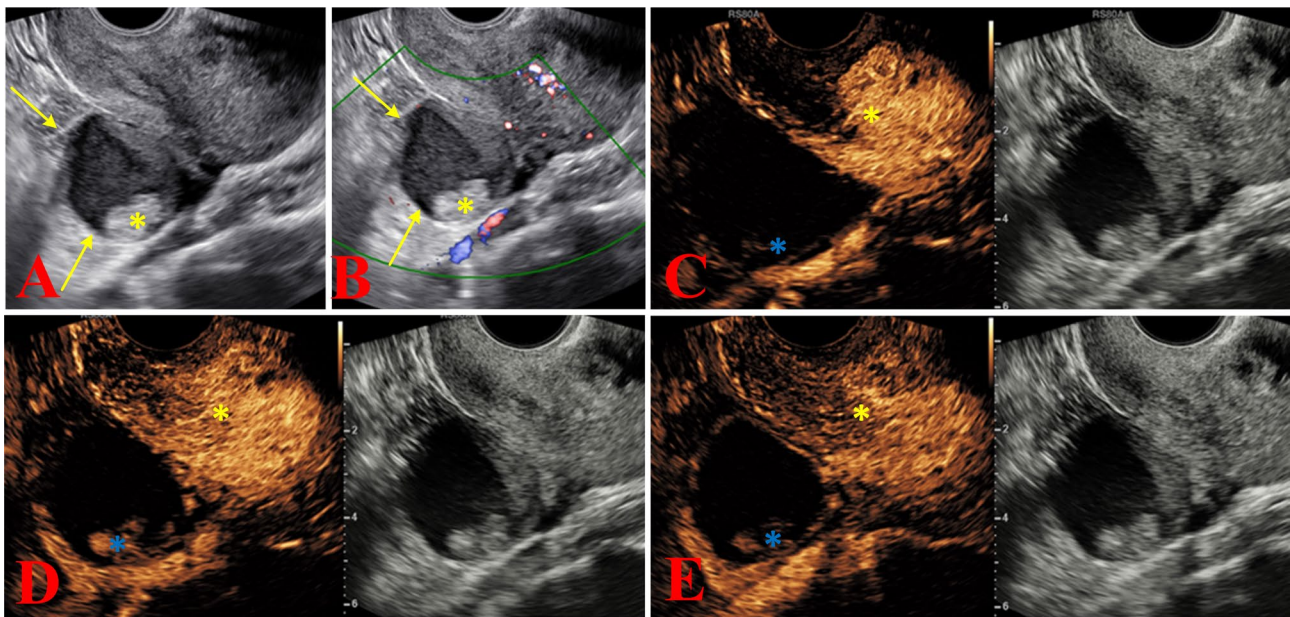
Ultrasonographic images of a serous cystadenoma in a 46-year-old woman. (A) The ultrasonic image shows a unilocular cyst (arrows) with a papillary projection (*) in the right adnexal region. (B) Color Doppler ultrasound reveals that there were no blood flow signals in the cyst wall and the papillary nodules (*) of the lesion (color score = 1), which was classified as O-RADS US v2022 category 4. (C, D) CEUS images of the lesion show late enhancement (blue * in C, score = 1) and hypoenhancement (blue * in D, score = 1) in comparison with myometrium (yellow *). (D, E) Compared with the myometrium (yellow *), the lesion shows a dynamic change in enhancement from hypoenhancement to hypoenhancement (score = 0). The CEUS score was 2, and this lesion was downgraded to O-RADS US v2022 category 3
